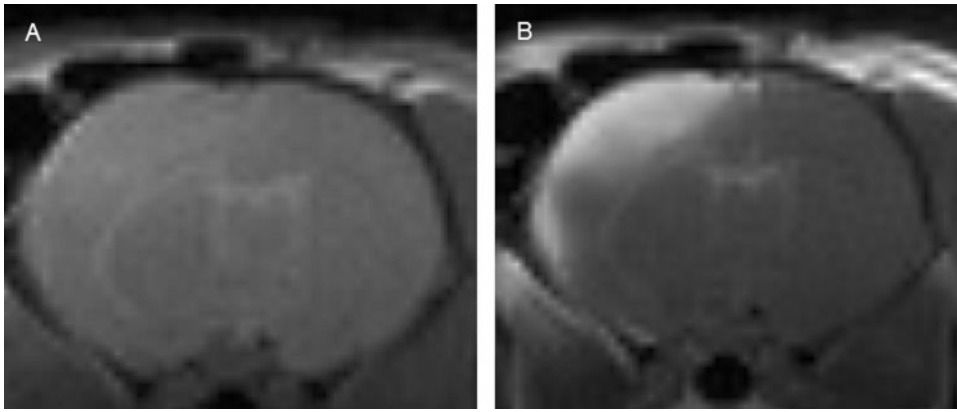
T1-weighted images before (A) and 20 minutes after (B) injecting gadolinium, allowing assessing the localization and extent of underlying blood–brain barrier damage by contrast enhancement 6 hours after trauma
